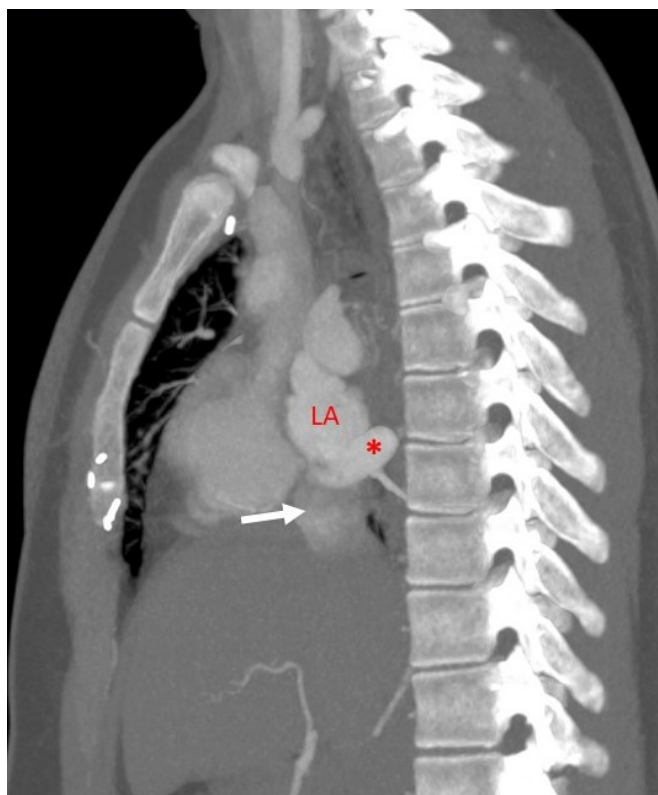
CT Angiography Sagittal MPR image- IVC (white arrow) seen opening into left atrium (LA) close to opening of right inferior pulmonary vein (red star).
